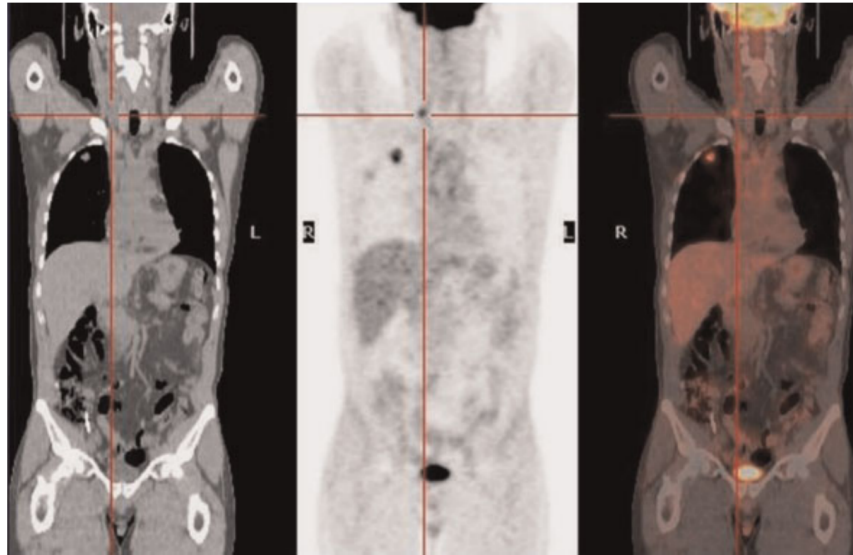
Example of multimodal image fusion. This picture shows the importance of complementing functional and anatomical imaging for the comprehension of the whole image. While CT (left) is not capable of providing the functional information captured by PET (center), their fusion (PET/CT, right) allows to precisely correlate the position of functional information to fine anatomical landmarks.
